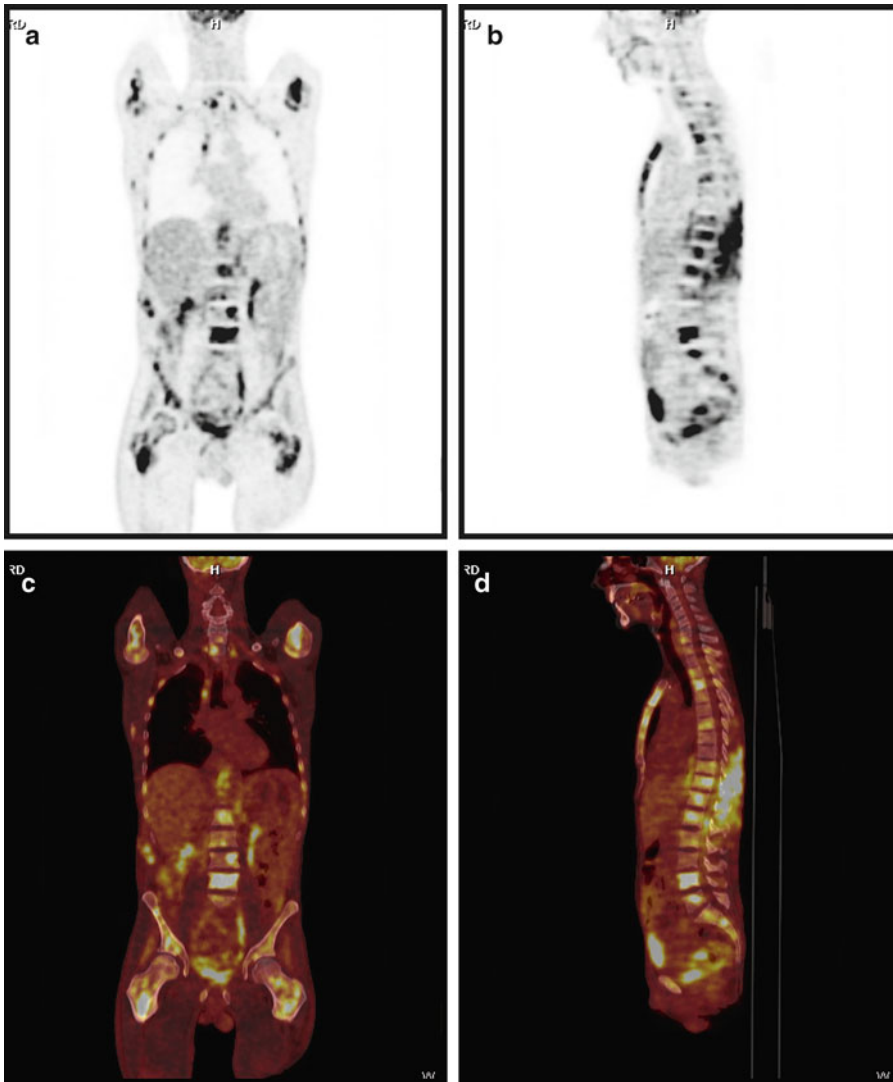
FDG PET/CT was performed in a 54-year old male for initial staging of NHL and revealed numerous foci of FDG-avid bone marrow lesions, characteristic of bone marrow infiltration of lymphoma. FDG-avid soft tissue
